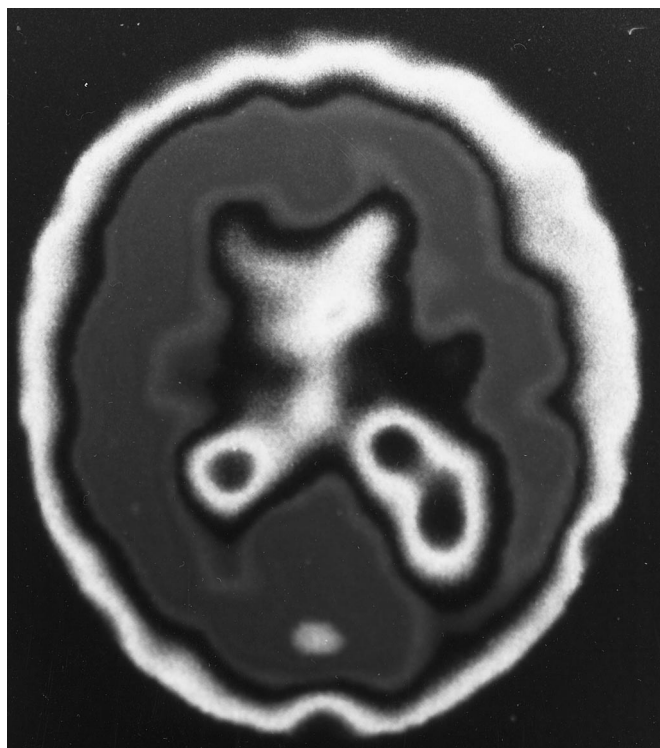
Hexylmethylpropylene amineoxine  $^{99}\text{Tc}$  SPECT showing reduced regional cerebral blood flow in the posterior regions of the left hemisphere (right side of figure).
